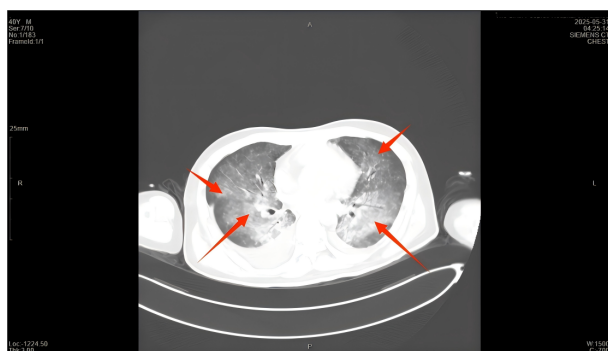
Chest CT display bilateral pulmonary exudative changes with local nodules and patchy opacities
